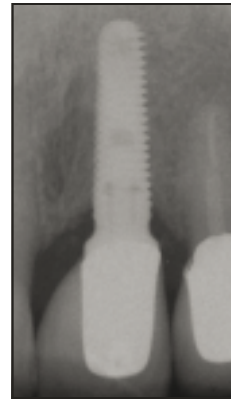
Radiographic follow-up 1-year after loading.
